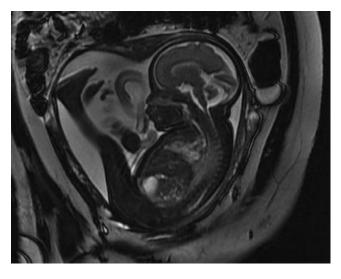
Fetal MRI demonstrating a normal fetus at 28 weeks' gestation.
